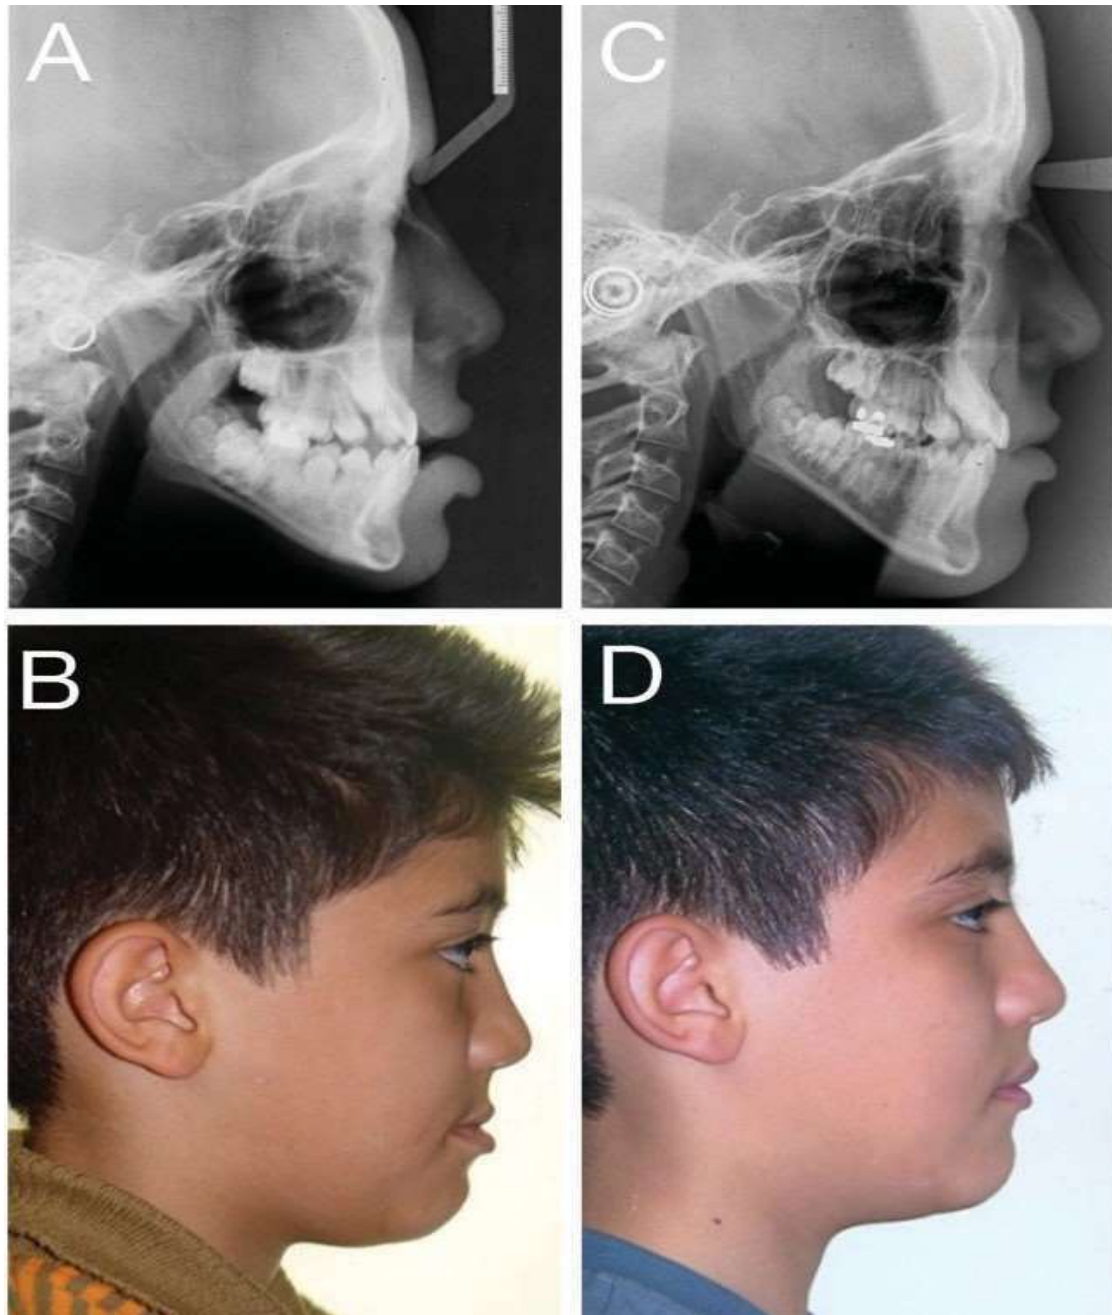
3 Treatment with the tongue plate. (A) Pre-treatment cephalometric radiograph; (B) pre-treatment profile; (C) post-treatment cephalometric radiograph; (D) post-treatment profile.
